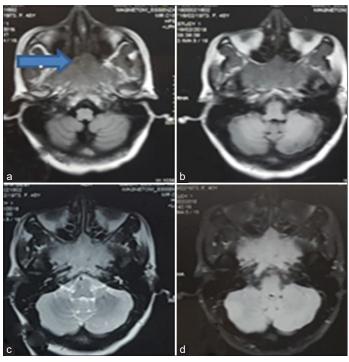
Magnetic resonance imaging axial T1 (a, b), T2 (c), and fluid-attenuated inversion recovery (d) images showing large soft-tissue isointense mass lesion arising from the clivus and extending into nasopharynx
